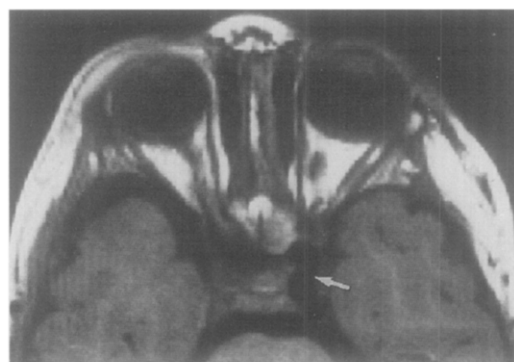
Magnetic resonance imaging shows nonvisualization of the right internal carotid artery and a patent left internal carotid artery (arrow).
